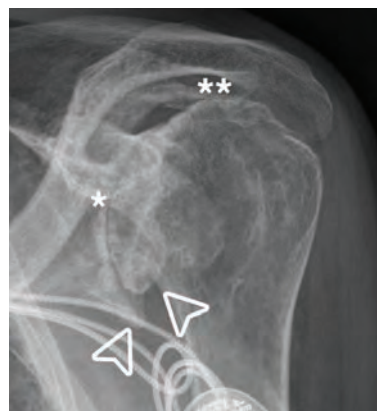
Radiographic features of shoulder OA.
